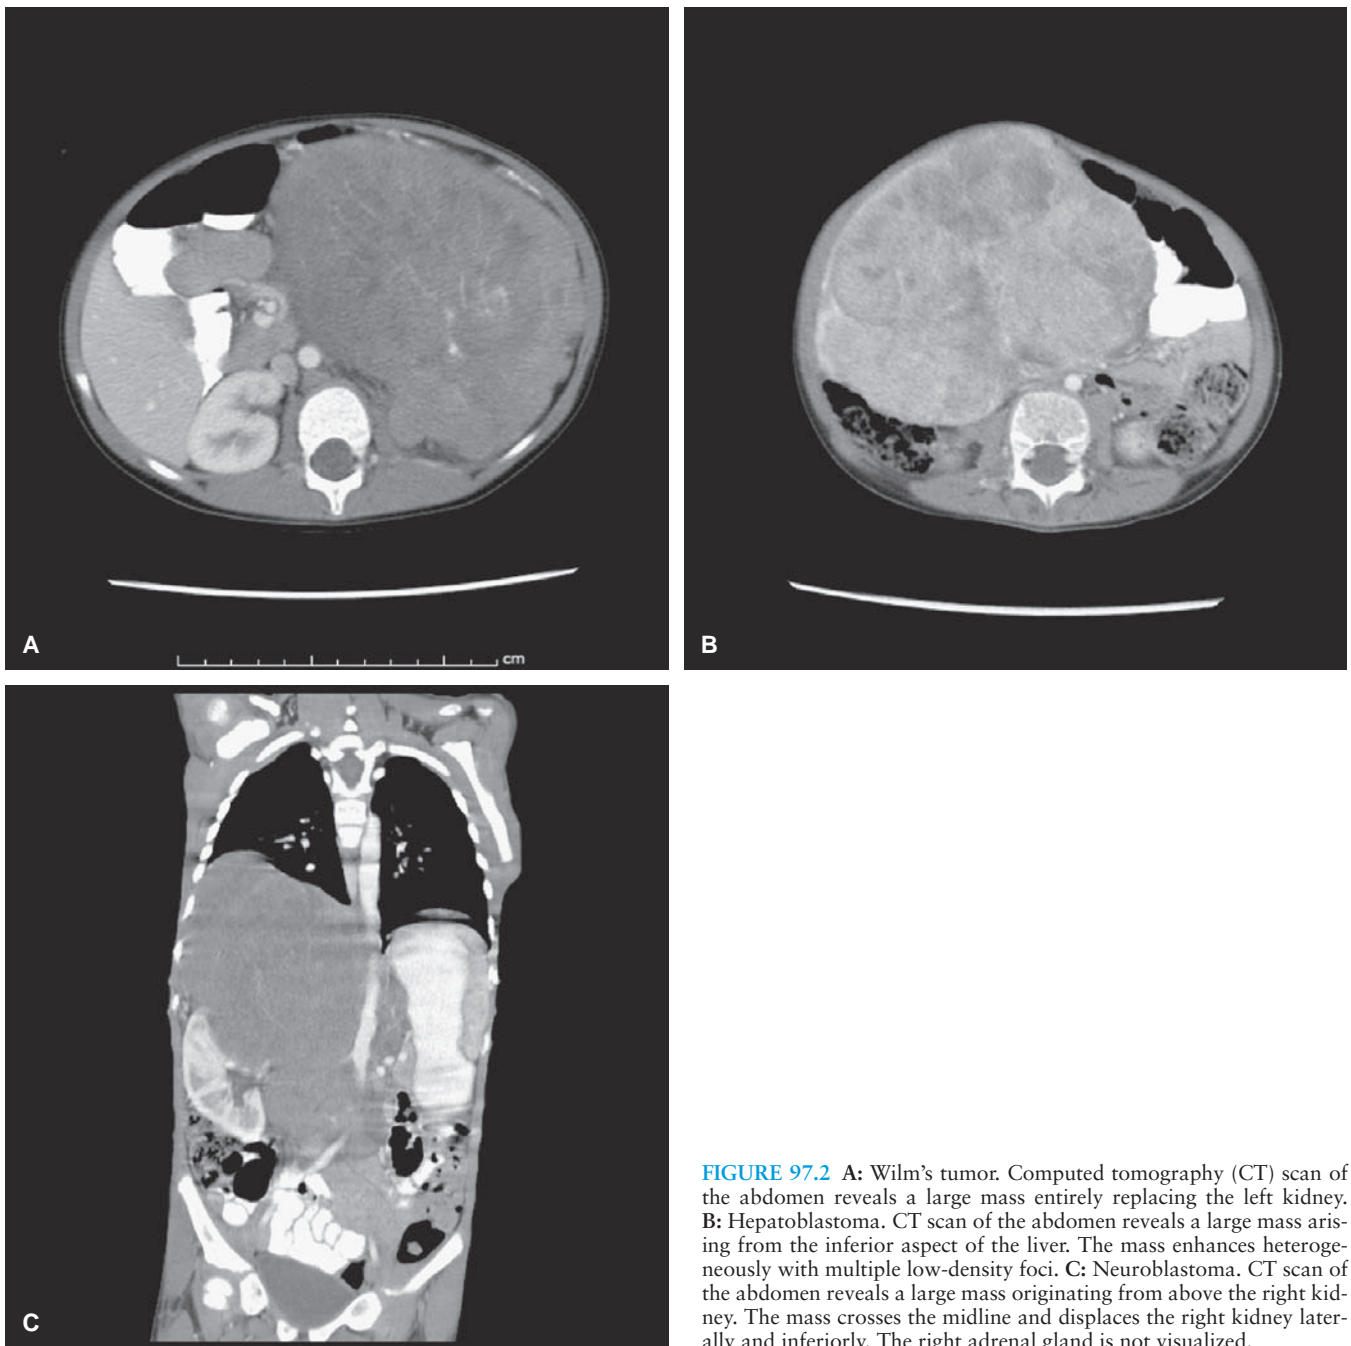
A: Wilm's tumor. Computed tomography (CT) scan of the abdomen reveals a large mass entirely replacing the left kidney. B: Hepatoblastoma. CT scan of the abdomen reveals a large mass arising from the inferior aspect of the liver. The mass enhances heterogeneously with multiple low-density foci. C: Neuroblastoma. CT scan of the abdomen reveals a large mass originating from above the right kidney. The mass crosses the midline and displaces the right kidney laterally and inferiorly. The right adrenal gland is not visualized.
